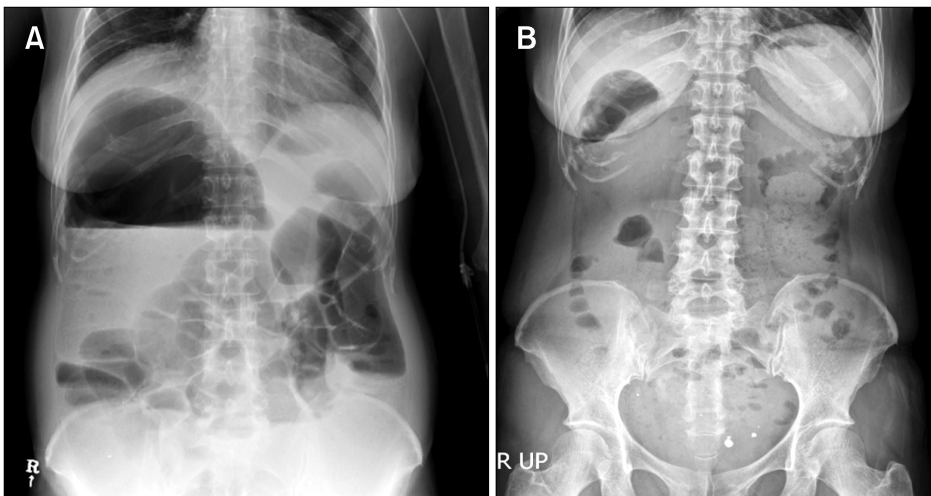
Abdomen erect X-ray. (A) The recurrence of hemimegacolon at the same site. (B) Improvement of recurrent hemimegacolon after medical treatment.
